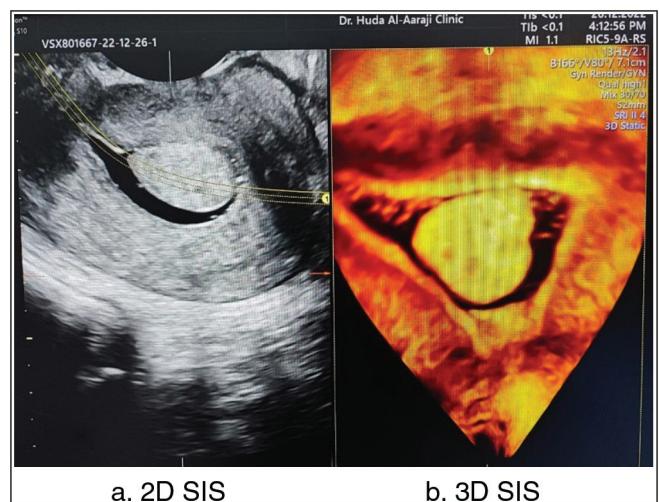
Endometrial polyp by saline infusion sonography (SIS) using 2D and 3D U/S (A. 2D U/S, B. 3D U/S)
